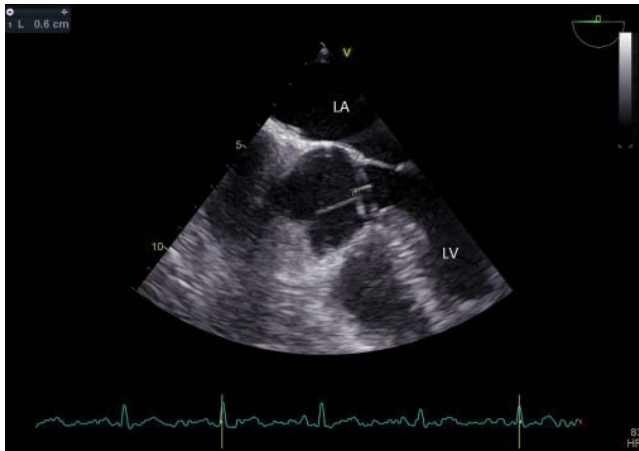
Transesophageal echocardiography-midesophageal 5 chamber view - a significantly reduced aortic vegetation (6 mm). LA left atrium, RA right atrium, LVOT left ventricle outflow tract, RVOT right ventricle outflow tract, LV left ventricle, Ao ascending aorta.
